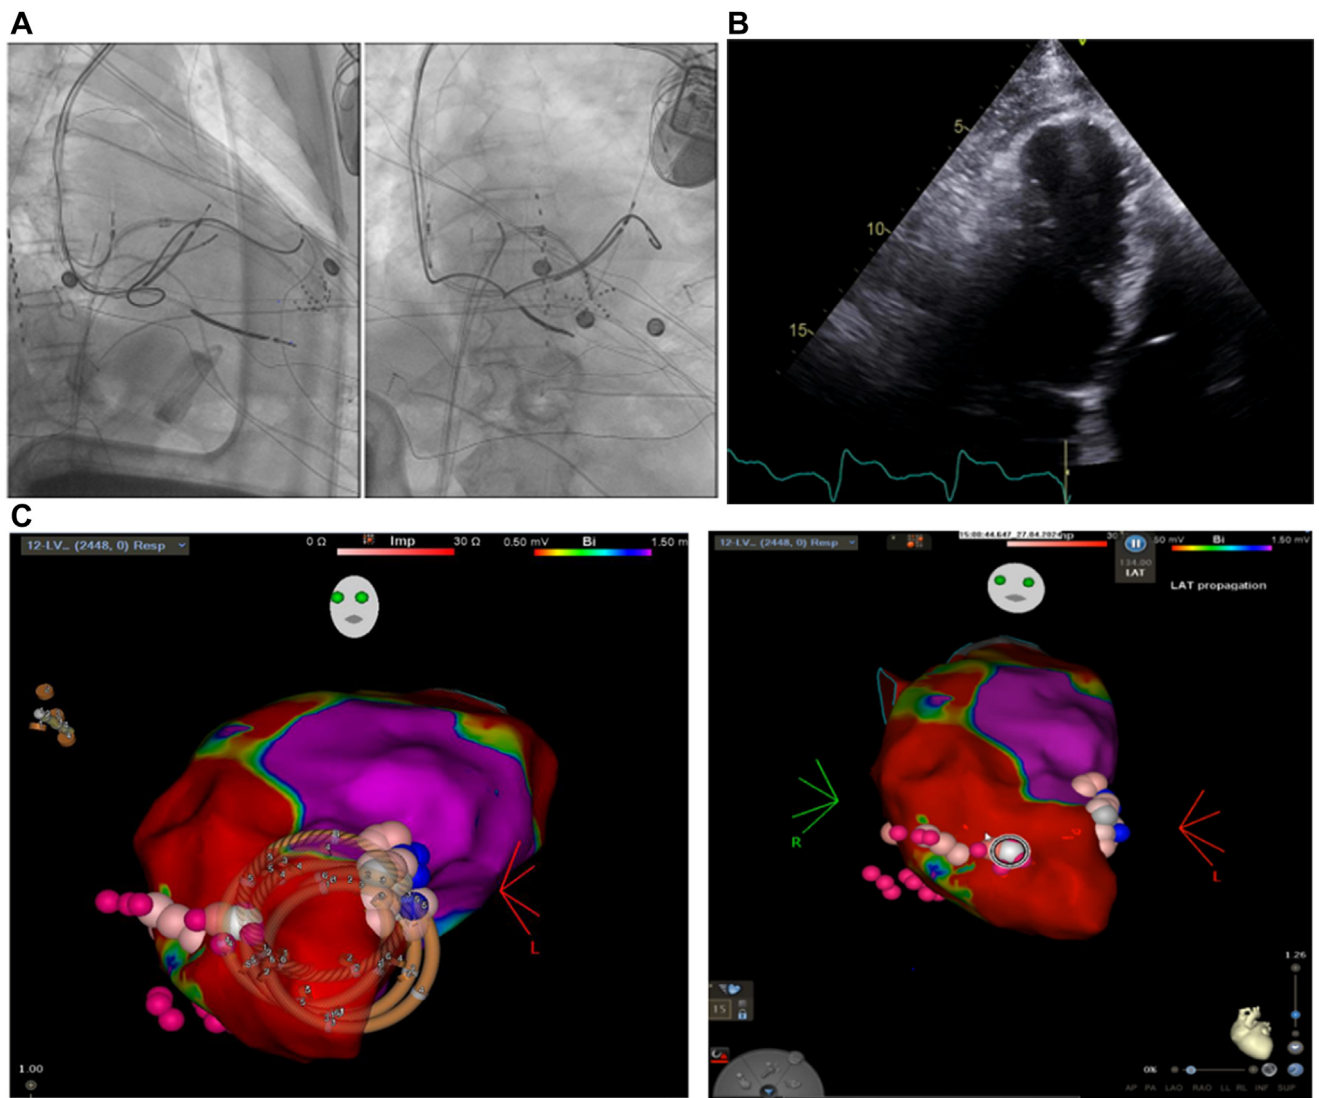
A: Fluoroscopy image showing FARAWAVE Catheter (Boston Scientific, Marlborough, MA) in the left ventricle. B: Ultrasonography scan demonstrating left ventricular apical aneurysm. C: Substrate map showing areas of ischemic scar (red) and healthy cardiac tissue (pink). D: Biventricular pacing vs S2 electrogram difference. E: Electrogram comparing pace map vs clinical ventricular tachycardia. F: Electrogram showing template match.
